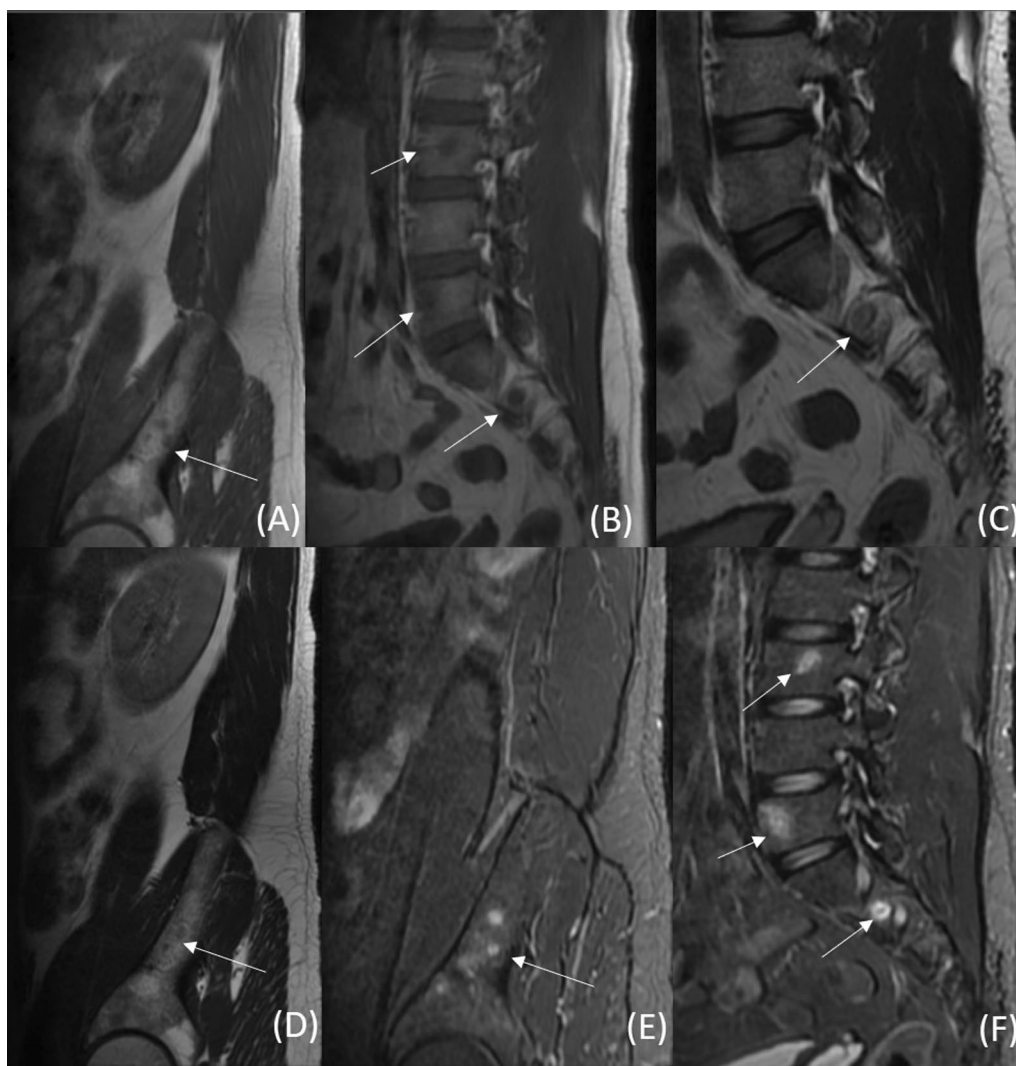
Multifocal skeletal tuberculosis with subcutaneous tubercular deposits. MRI spine of a 35-year-old male shows multiple lesions (white arrows) in lumbar and sacral vertebrae and iliac bone. The lesions are hypointense on T1W (A and B) and T2W images (C and D) and hyperintense on STIR (E and F)
